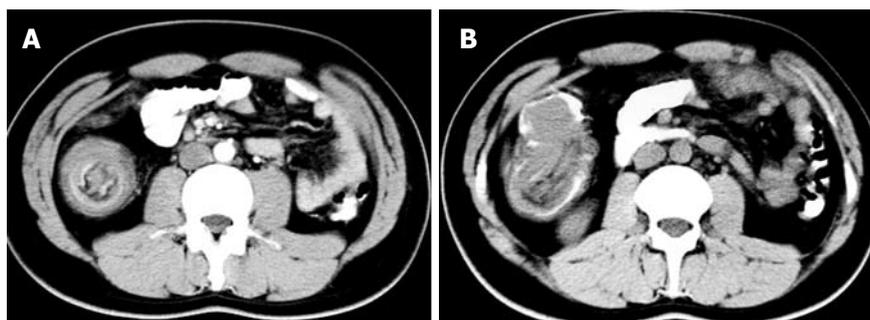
Abdominal computed tomography in adult intussusception. A: The characteristic “target”-shaped soft-tissue mass with a layering effect of a 29-year old male patient with a diffuse, small B-cell (Burkitt-like) non Hodgkin lymphoma of the ileum who developed an ileo-colic intussusception; B: A “sausage”-shaped soft tissue mass in the ascending colon of the same patient.
